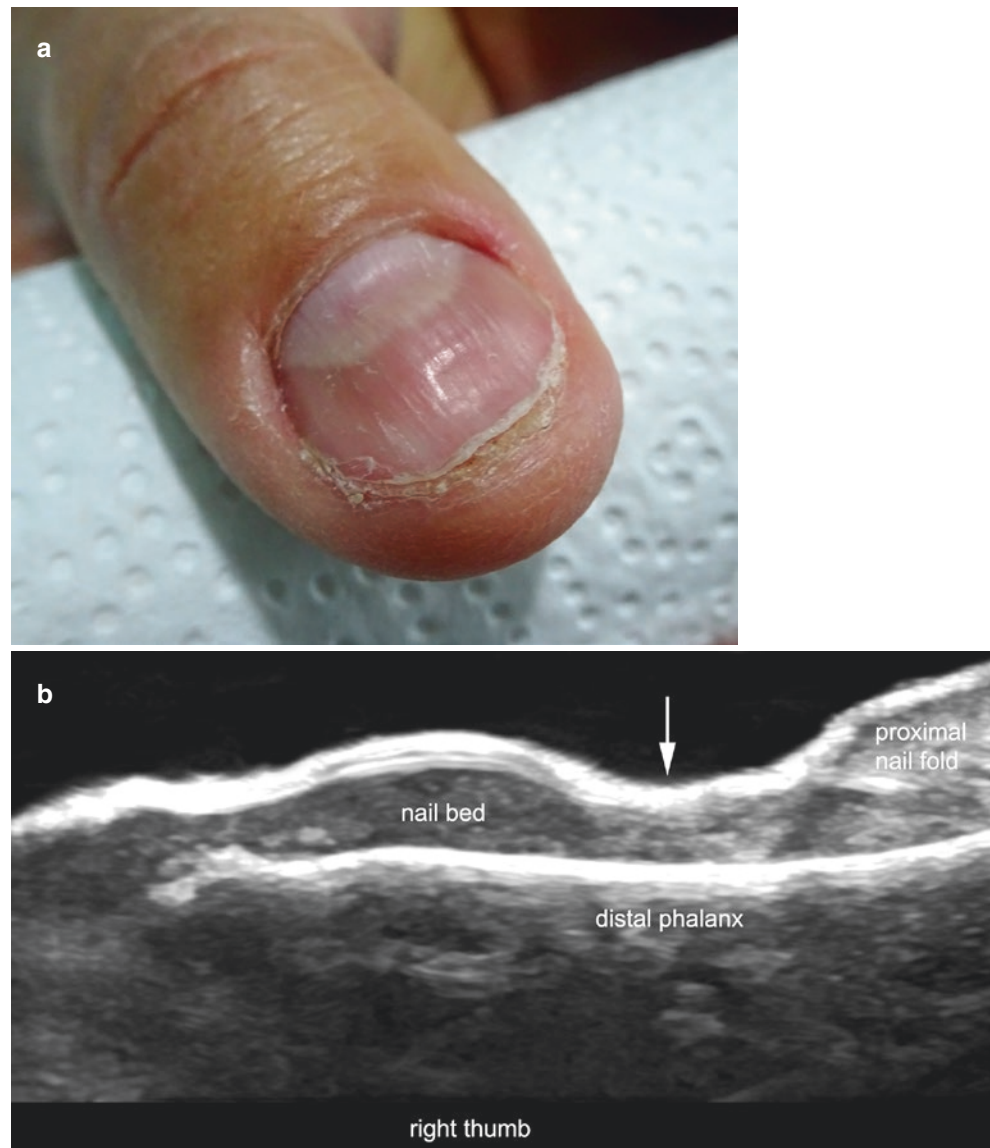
Granuloma. (a) Clinical image of the nail of the right thumb. (b and c) Ultrasound images (b, greyscale; c, power Doppler; longitudinal views) show ill-defined thickening and hypoechoogenicity of the nail bed with thinning of the proximal part of the nail bed (arrow in b), thickening of the middle part, and thinning of the distal part. On power Doppler (c), a slight increase of vascularity is detected in the distal part of the nail bed (in colors). Notice that the bony margin of the distal phalanx is unremarkable.
